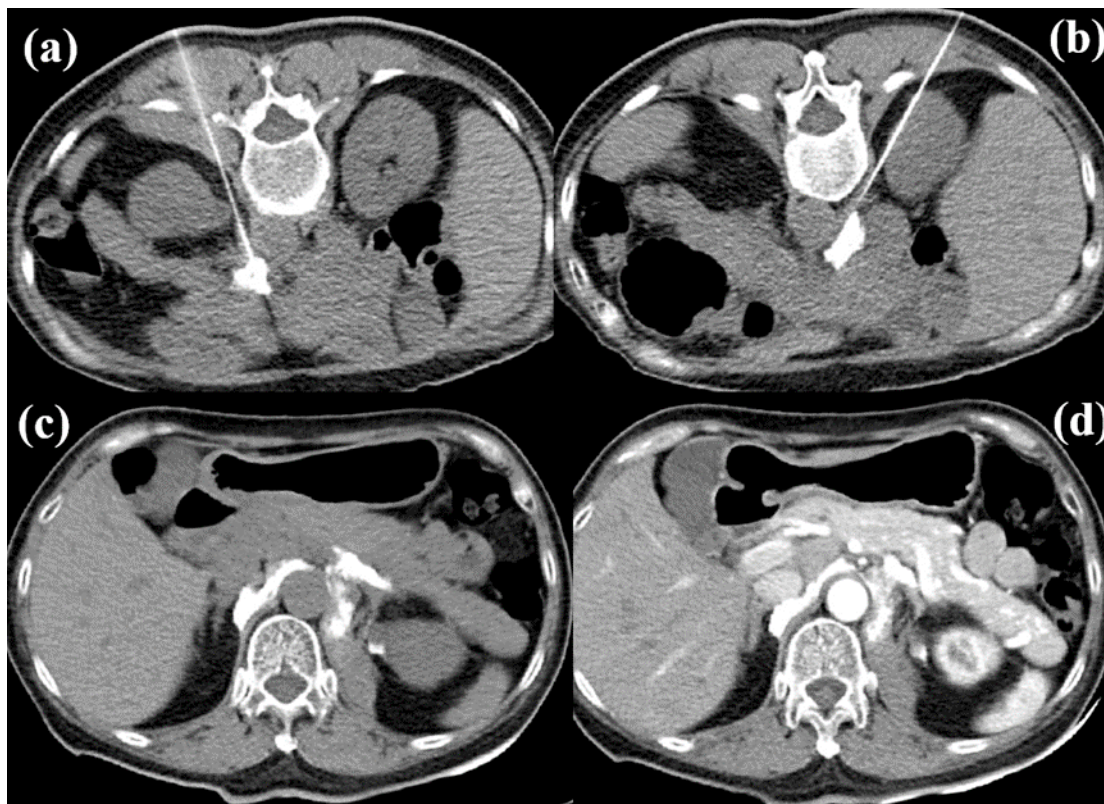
(a) Under computerized tomography (CT)-guidance, a 22-gauge Chiba needle was introduced to the left celiac plexus to which neurolysis was subsequently achieved by administering a mixture of 4 c.c. ethanol + 4 c.c. 2% Xylocaine + 2 c.c. contrast medium (a total of 10 c.c. mixture); (b) The same procedure was performed to block the right celiac plexus; (c) Bilateral celiac plexus block (CPB) was successfully achieved using the ethanol+xylocaine+contrast mixture, as evidenced by bilateral diffusion of the contrast on CT image; (d) The bilateral CPB at the level of celiac trunk was confirmed through a computerized tomography-angiogram (CTA) image.
